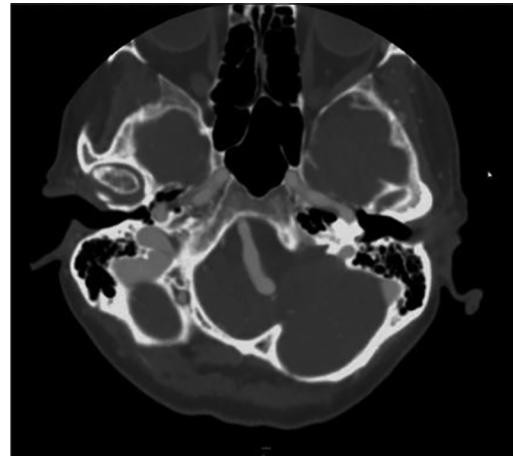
Preoperative computed tomography angiography (CTA) showing a tortuous left vertebral artery crossing the midline
